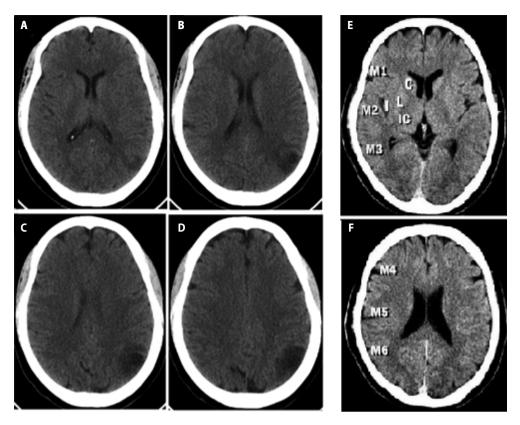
A–D sequential axial non-contrast CT images of brain reveal hypodense area of infarction at left posterior parietal region (M3 and M6 regions); ASPECTS = 8. E–F sequential axial non-contrast CT images of brain reveal ganglionic and supraganglionic levels and ASPECTS scoring: one point is subtracted for each affected area on brain CT
